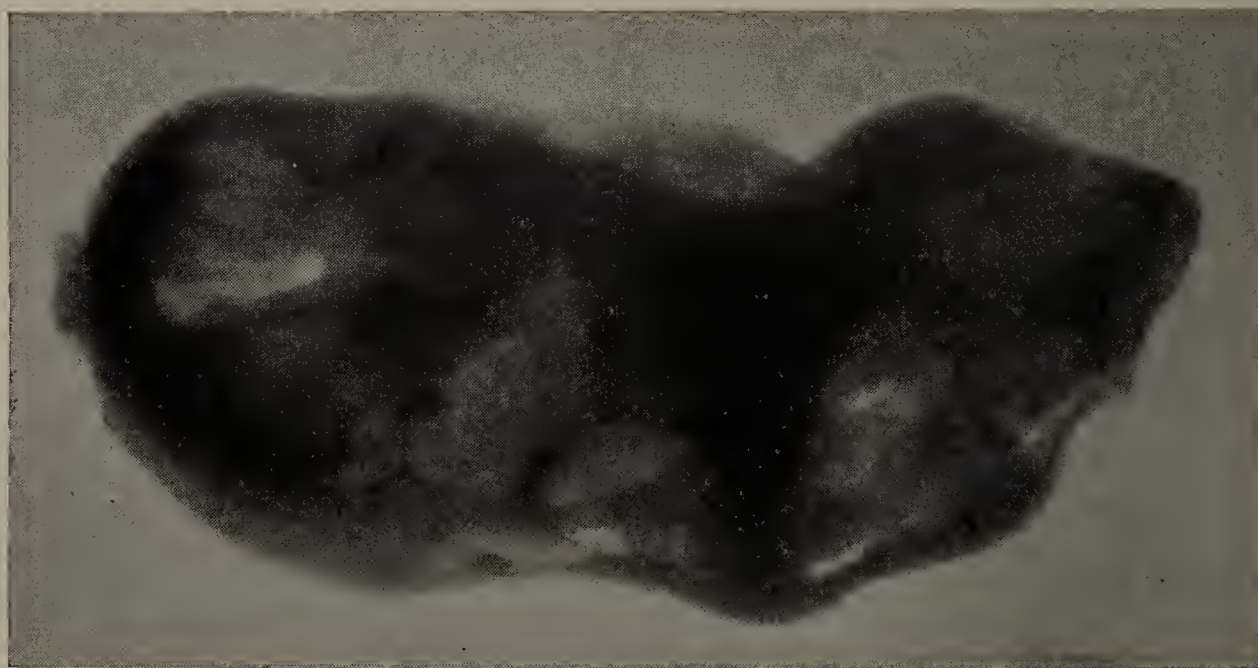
Radiograph of the kidney after removal.
